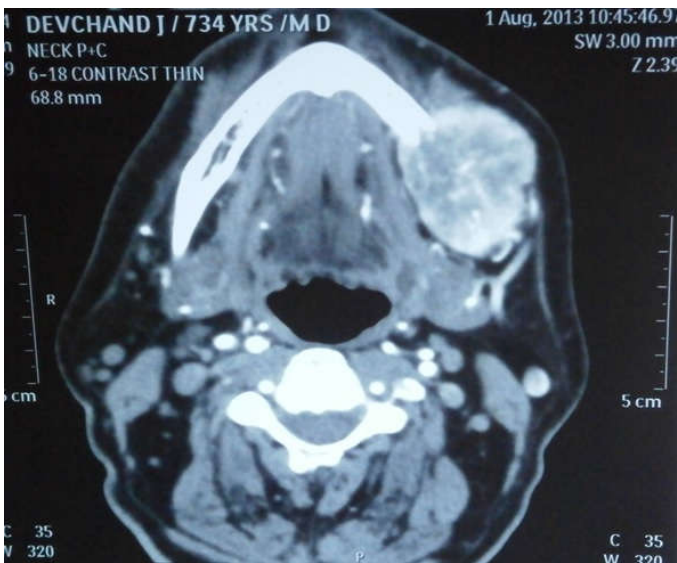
CT scan- 8x6x4 cm growth eroding and expanding the mandible
